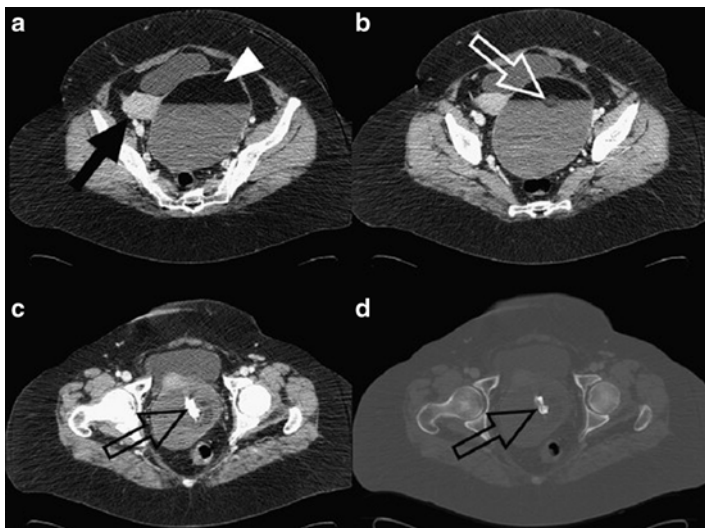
Ovarian teratoma. Contrast-enhanced CT scan (a, b) shows well-defined ovarian tumor with fat-fluid level (*white arrowhead*), round mass of matted tuft of hair (*white open arrow*), and enhancing lobulated soft-tissue component (*black arrow*) in lateral wall. A toothlike calcification in inferior wall is visible (*black open arrow*) in (c, d) scans (Reprinted from Saba et al. [59], with permission from Elsevier)
